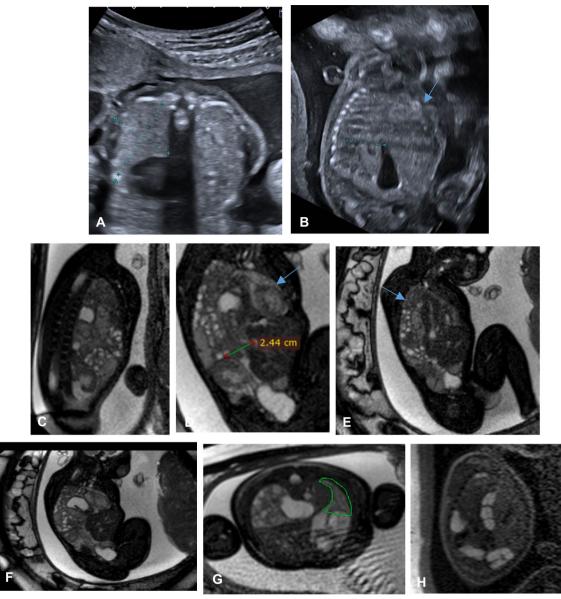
A 39-year-old pregnant female with antenatal US showing large congenital diaphragmatic hernia. Ultrasound findings: A, B Axial and coronal sections of the fetal abdomen and chest showing left diaphragmatic hernia with herniation of the stomach and bowel into chest. MRI Findings: C, D, E sagittal T2WI, B coronal T2WI, and E axial T2WIs showing a large left-sided rather posterior diaphragmatic defect with herniation of the whole stomach, small bowel loops, and left hepatic lobe into whole left hemithorax with consequently marked compression of the left lung, shift and compression of heart to the left side with compressed right lung (arrowed). F sagittal TWI showing high meconium signal within herniated colon into the left hemithorax. Combined US and MRI Diagnosis: Large left-sided intra-pleural hernia with marked mass effect on both lungs and heart with concluded poor postnatal survival rates. Termination by C.S at GA 37 weeks
